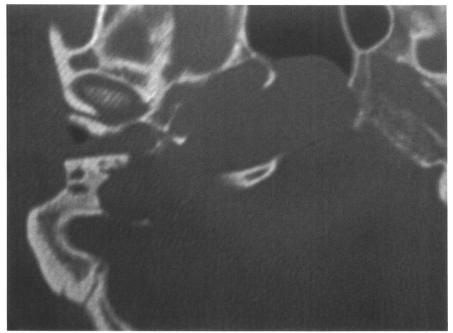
Infralabyrinthine-apical cholesteatoma extending to the sphenoid sinus. CT, axial section. The whole petrous bone and the lateral aspect of the clivus are completely eroded by an osteolytic lesion. The horizontal portion of the carotid canal is surrounded by the tumor, the posterior wall of the sphenoid sinus is missing and the tumor involves the sinus itself.
